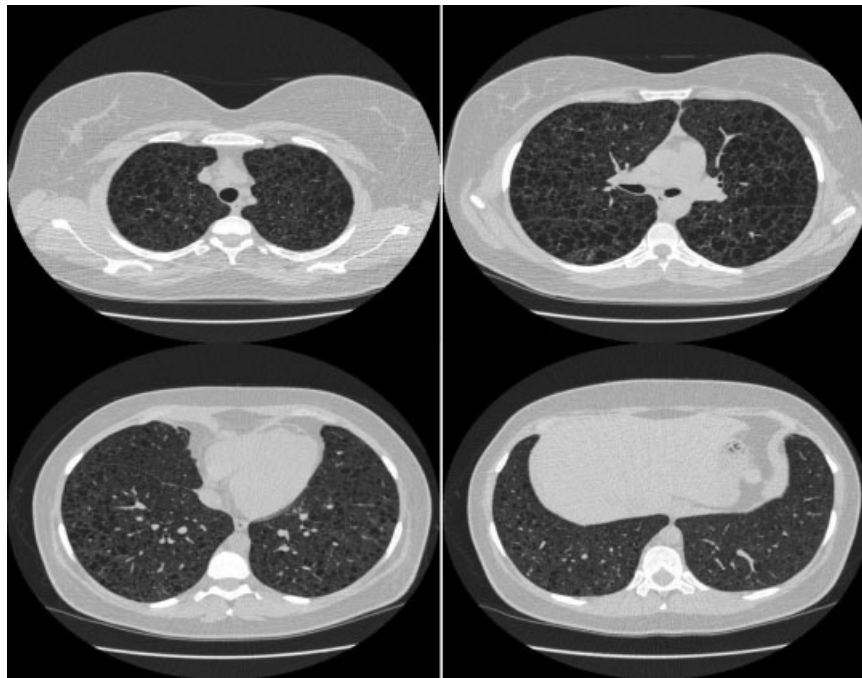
Transbronchial biopsy–based diagnosis of lymphangiomyomatosis (LAM) radiology. High-resolution computed tomographic (CT) scan images of a patient with cystic disease who was initially diagnosed with pulmonary Langerhans cell histiocytosis based on CT interpretation by two expert chest CT radiologists. The patient was initially excluded from a clinical trial based on these opinions. Subsequent transbronchial biopsy was diagnostic for LAM, and the patient was enrolled in the trial.
